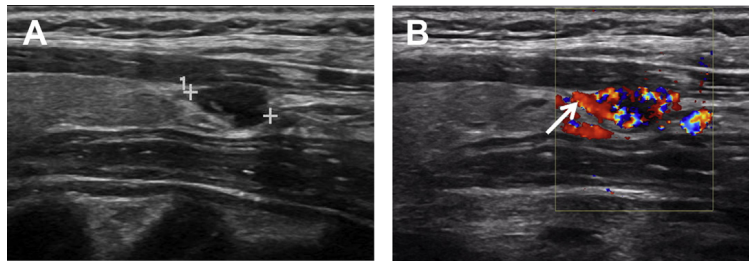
Typical appearance of inferior parathyroid adenoma. Sagittal views show the typical grayscale (A) and color Doppler (B) appearance of an inferior parathyroid adenoma (cursors in A). It is a solid, ovoid, well-defined, hypoechoic nodule immediately inferior to the thyroid gland with increased internal vascularity and a polar vessel (arrow in B) exiting the superior border of the nodule.
